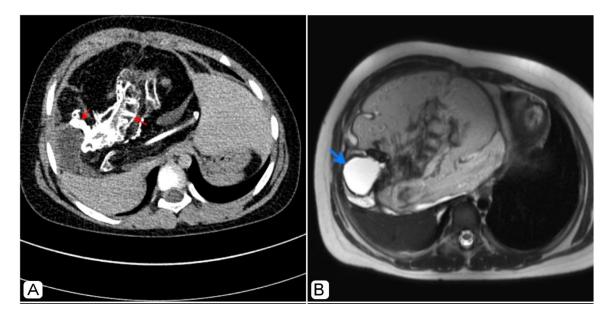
A CT scan showing a vertebral column and a skull base (red arrows) (A). Axial T2Wt MRI demonstrating a cystic component (blue arrow) laying above the cranium (B).
